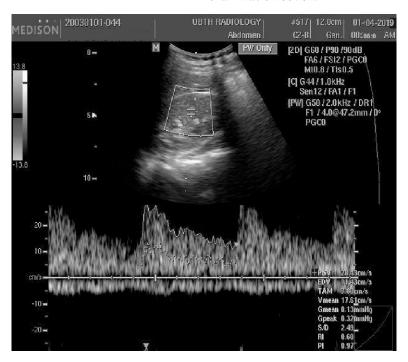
Spectral Doppler tracing of the right middle pole inter-lobar artery.
